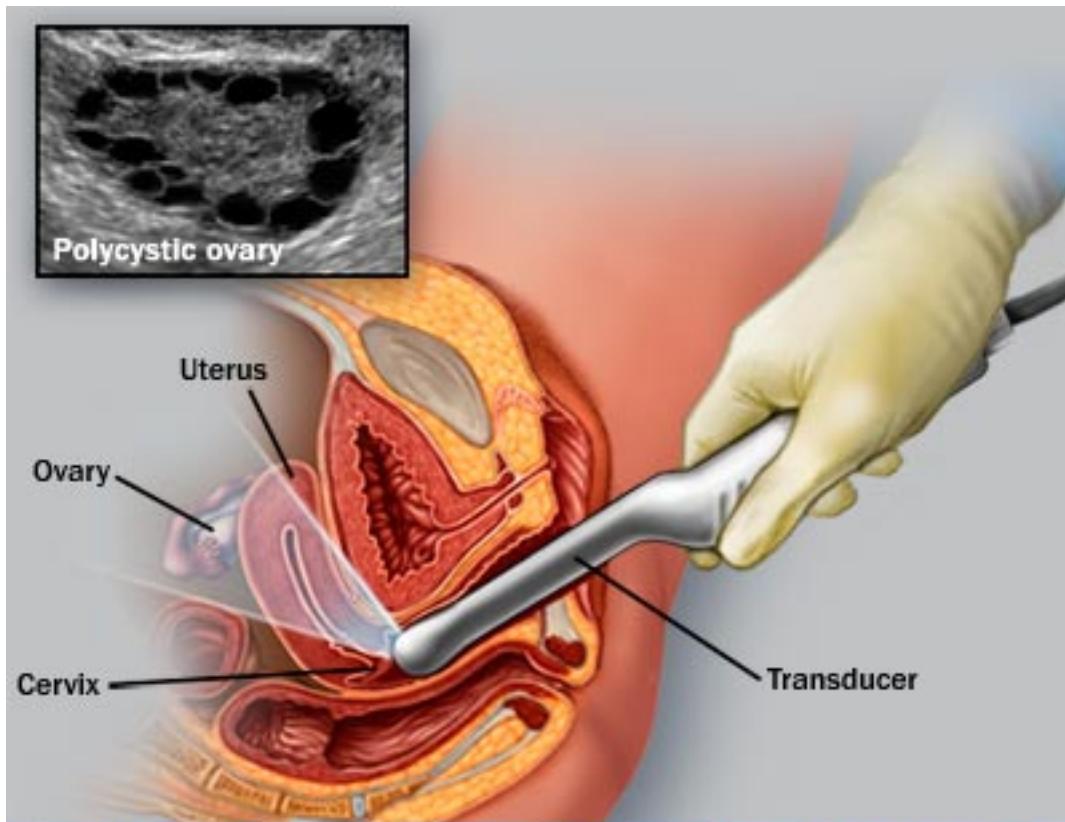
Visual representation of the inside of the body during the transvaginal ultrasound. The image in the top left depicts polycystic ovaries, small cysts form on the outer edges of the ovaries. (35)
